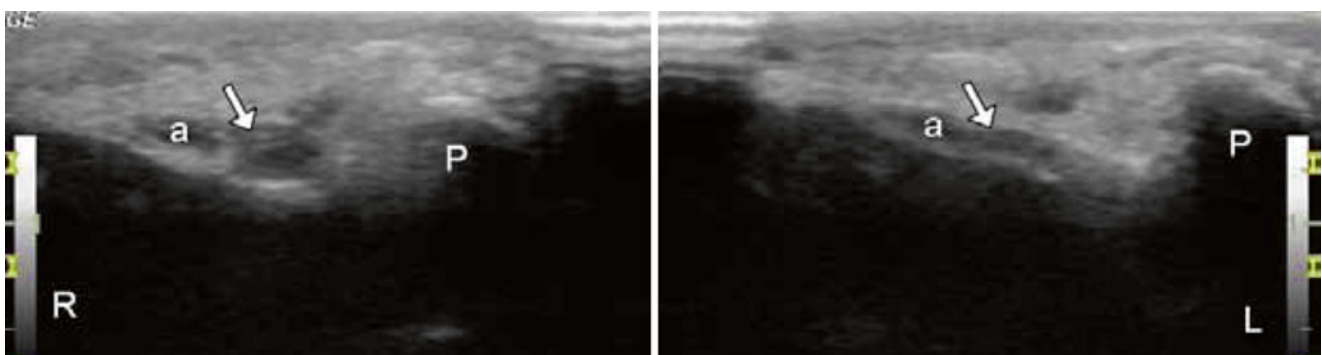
Ultrasound axial view of the both wrists showing the ulnar nerves in the ulnar tunnels (arrows), demonstrating enlargement of the ulnar nerve on the right (From Yalcin et al. [21]. Reprinted with permission from American Society of Interventional Pain Physicians)
